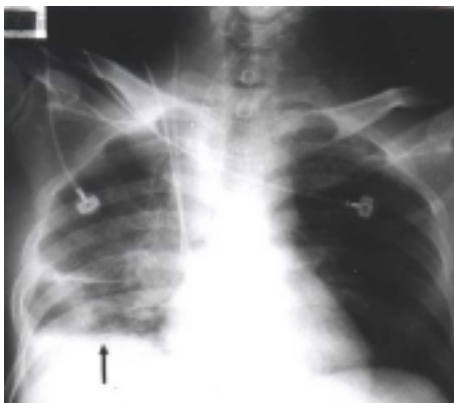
Chest roentgenogram showed right pleural effusion (arrow).
